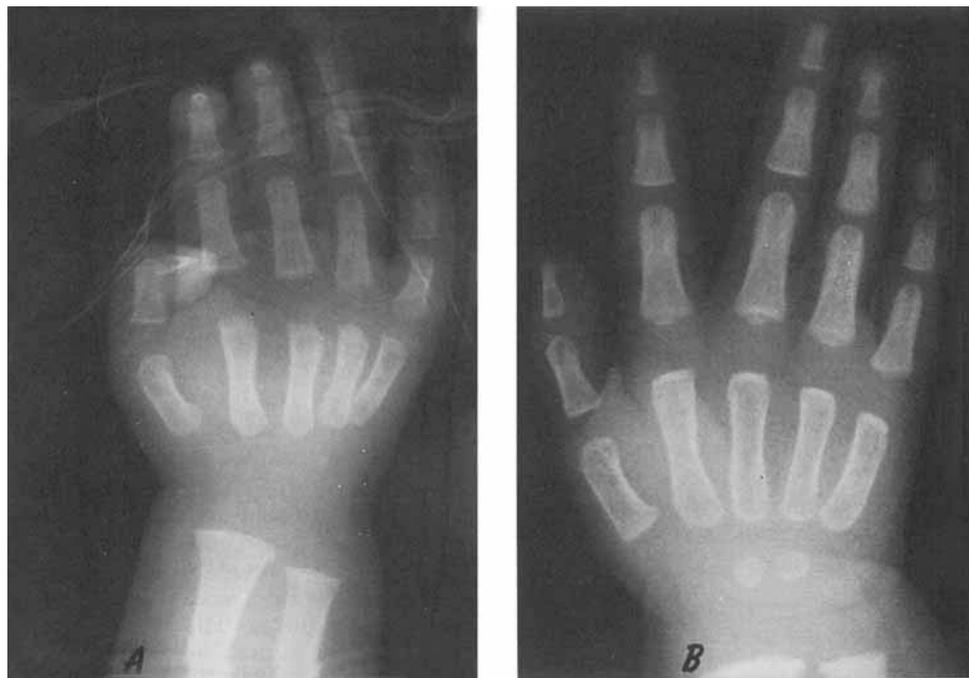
Radiographs of the right hand at age 4 months (A) and at 16 months (B). Note short distal phalanges on both radiographs.
